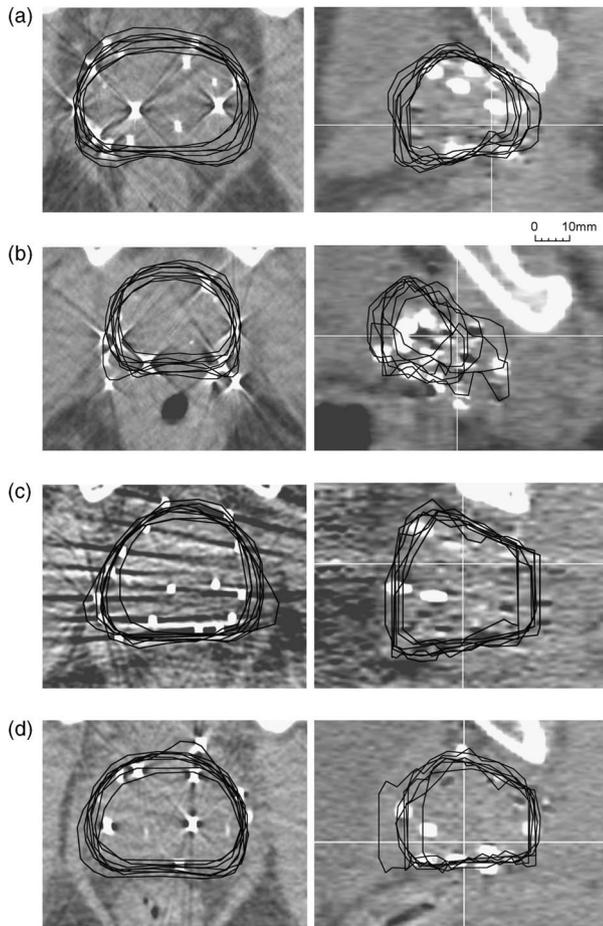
Transverse (left) and sagittal (right) CT images of patients 1 to 4, (a) to (d), respectively, showing the prostate outlines drawn by the nine radiotherapy centres.
